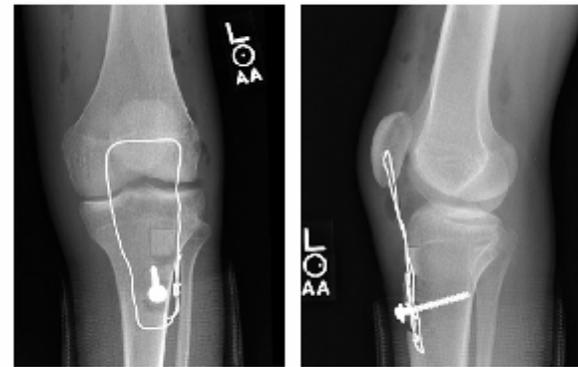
Anteroposterior (Fig. 2-A) and lateral (Fig. 2-B) radiographs of a knee in maximum extension following patellar tendon and tibial tubercle advancement. The tibial tubercle was removed as a block of bone. A wire was covered distally for the tibial tubercle by removing the cortical surface. (This cortical piece is typically transposed proximally to the original site of the tibial tubercle and rounded into position.) The tubercle is advanced until the distal pole of the patella is on the joint line. The entire repair in this patient is protected by a 16-gauge drain inserted Luque-wire tenon band placed transversely through the patella and through a transverse drill hole in the tibia and tightened. When Luque wire is used, it is typically removed six to eight weeks after the surgery. Currently, FiberTape is used as tension band and removal and fixation is not required.
